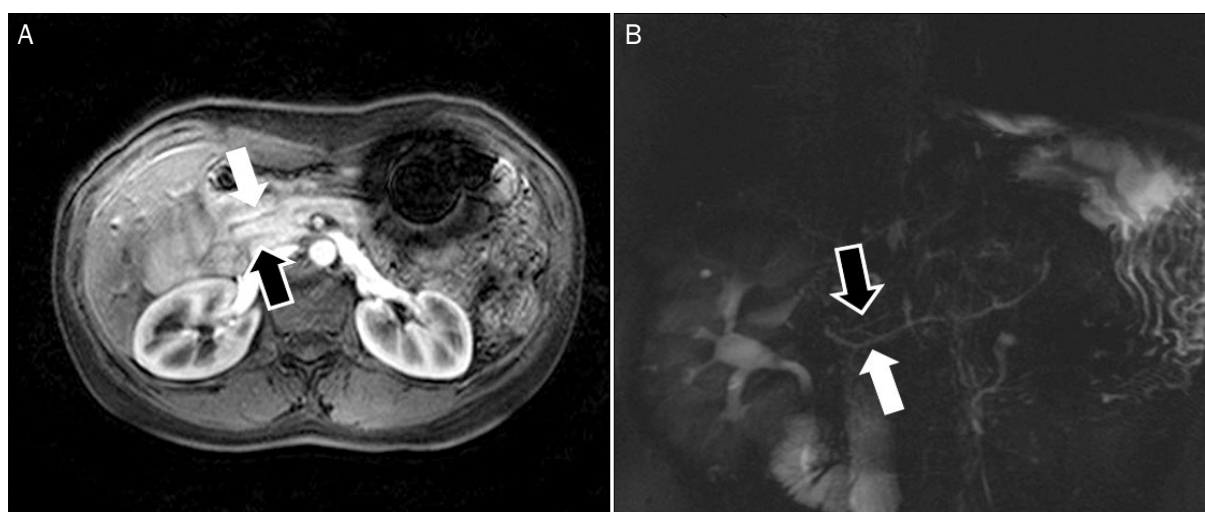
Axial gadolinium-enhanced T1-weighted image (A) and MRCP image (B) showing the dorsal pancreatic duct (white arrows) directly connected to the accessory pancreatic duct, which drained into the minor ampulla. There was no communication between the ventral duct (black arrows) and the dorsal duct, but the ventral duct entered the major ampulla (A, B). MRCP, magnetic resonance cholangiopancreatography.
